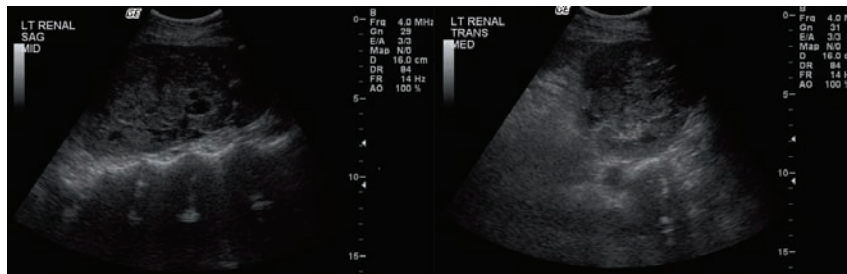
Ultrasound images of questionable renal mass.
